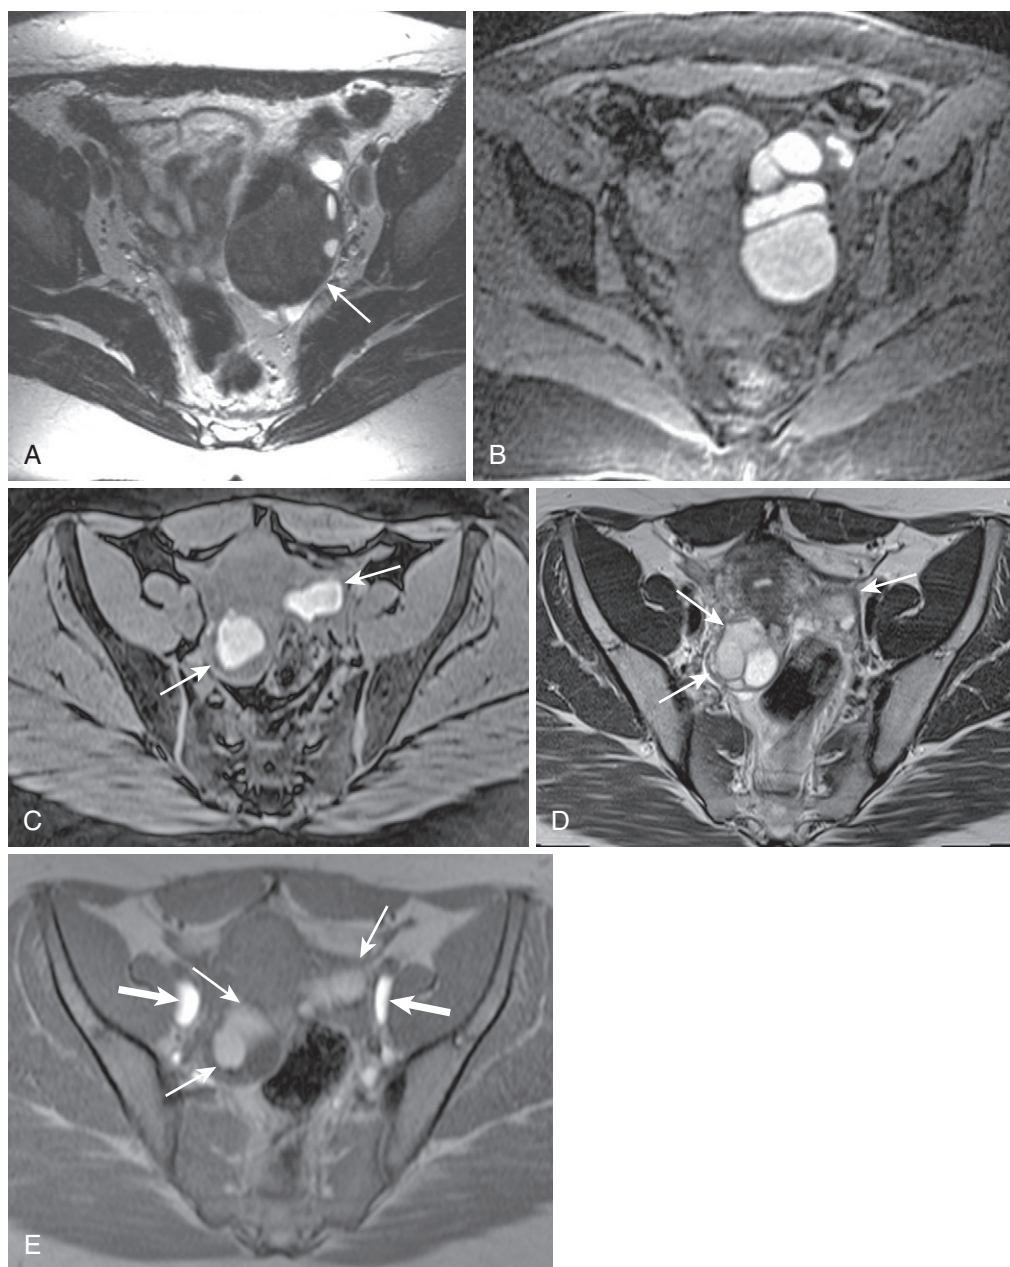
Endometriomas. Another typical case of endometriosis reveals an ill-defined left adnexal lesion with marked T2-shortening (*arrow* in A) combined with corresponding hyperintensity on T1-weighted fat-saturated image (B)—signifying concentrated hemorrhage—lesion multiplicity, and nonspherical morphology. C-E, In a different patient, multiple irregular lesions (*arrows* in C and E) with similar signal characteristics on the T1-weighted fat-suppressed image (C) with shading—albeit less profound—on the T2-weighted image (*arrows* in D) typify endometriosis. E, The T1-weighted in-phase gradient echo image reveals additional bilateral hyperintense lesions in the iliac fossa (*thick arrows*) not to be confused with endometriomas (or other hemorrhagic or fatty lesions). Flow-related enhancement accounts for hyperintensity in the iliac veins, in this case. Remember that gradient echo images are time-of-flight images (without the parameter modifications of dedicated vascular sequences) and prone to the in-flow effect (especially in two-dimensional sequences in the case of the entry slice with respect to the vessel).
